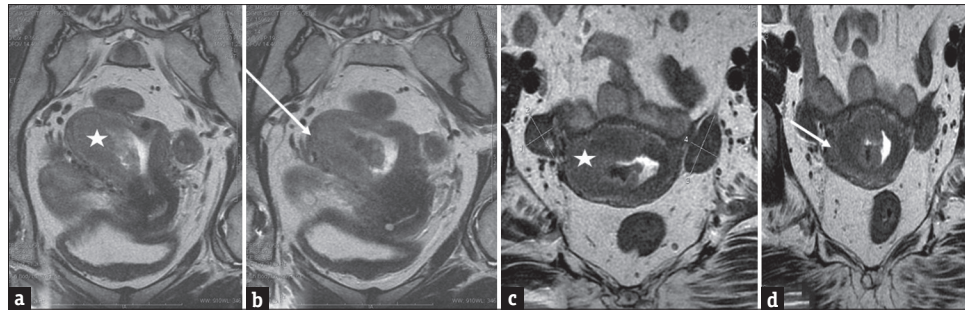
Stage 1B endometrial cancer in a 53-year-old female. (a and b) Coronal oblique T2-weighted magnetic resonance images demonstrates a tumor (*) with invasion of the myometrium and poor tumor-to-myometrium contrast (arrow). (c and d) Axial T2-weighted magnetic resonance image shows a large iso- to hypointense endometrial tumor (*) with poor tumor-to-myometrium contrast (arrow) and invasion of the outer half of the myometrium (short arrow)
